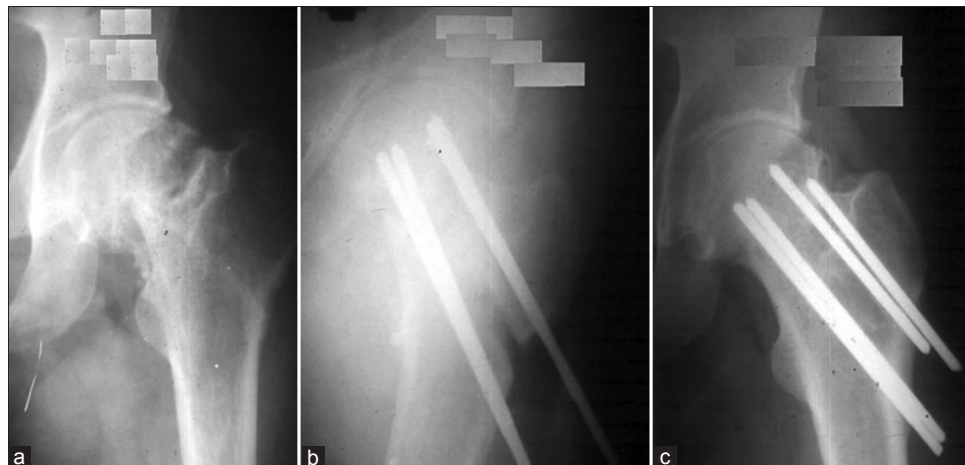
(a) Radiograph of left hip of 34 year old male patient with nonunion femoral neck fracture since four years, (b) treated with TFAO, (c) a postoperative followup X-ray at 12 months, excellent union achieved
